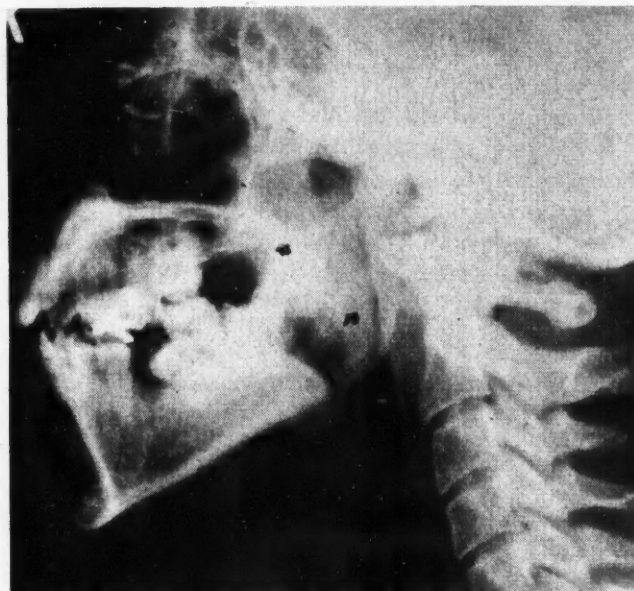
Roentgenogram (lateral view of neck) showing broken-off suture needle in region of right tonsillar fossa.
